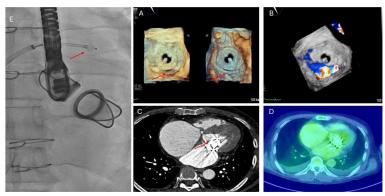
A. 3D TEE showing paravalvular defects. B. With color flow. C. Cardiac CT is used for assessment of the mittal prosthesis. D. PETCT image is showing no uptake on the mittal prosthesis, ruling out IE. E. Fluoroscopic image showing attempted PV leak closure with AVP II device under TEE guidance
